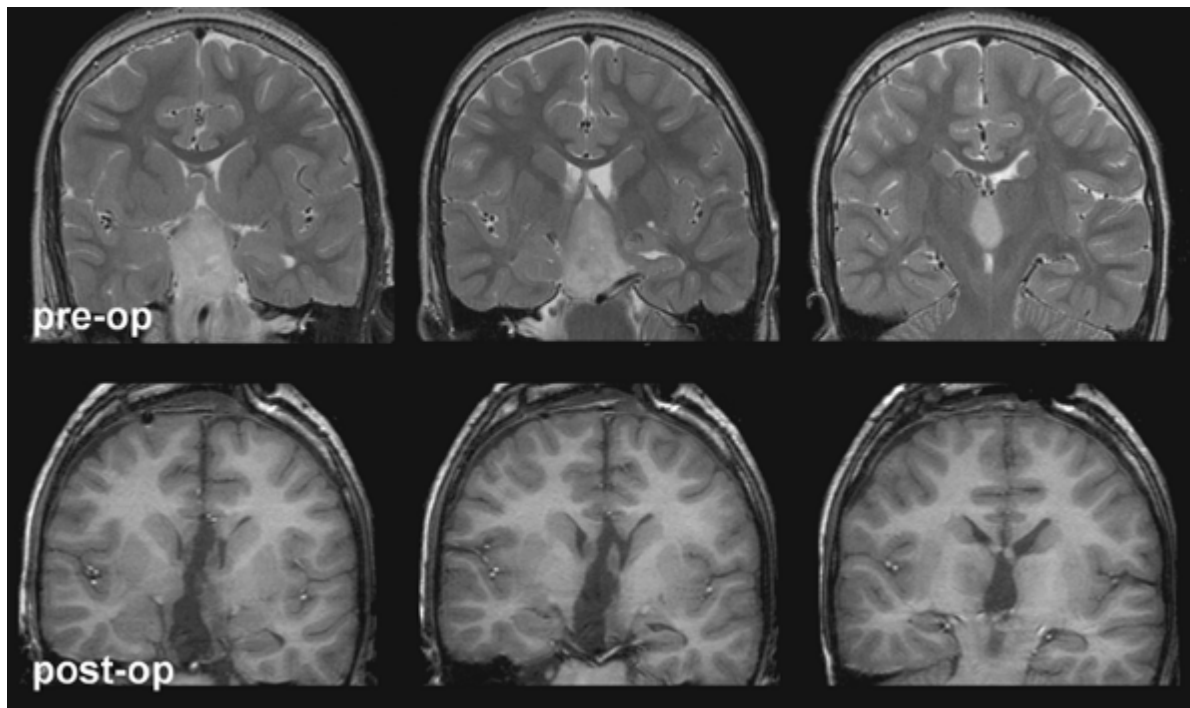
Coronal magnetic resonance images of a child with a large bilateral hypothalamic hamartoma and intractable gelastic seizures, before (top row) and after (bottom row) transcallosal resection.
